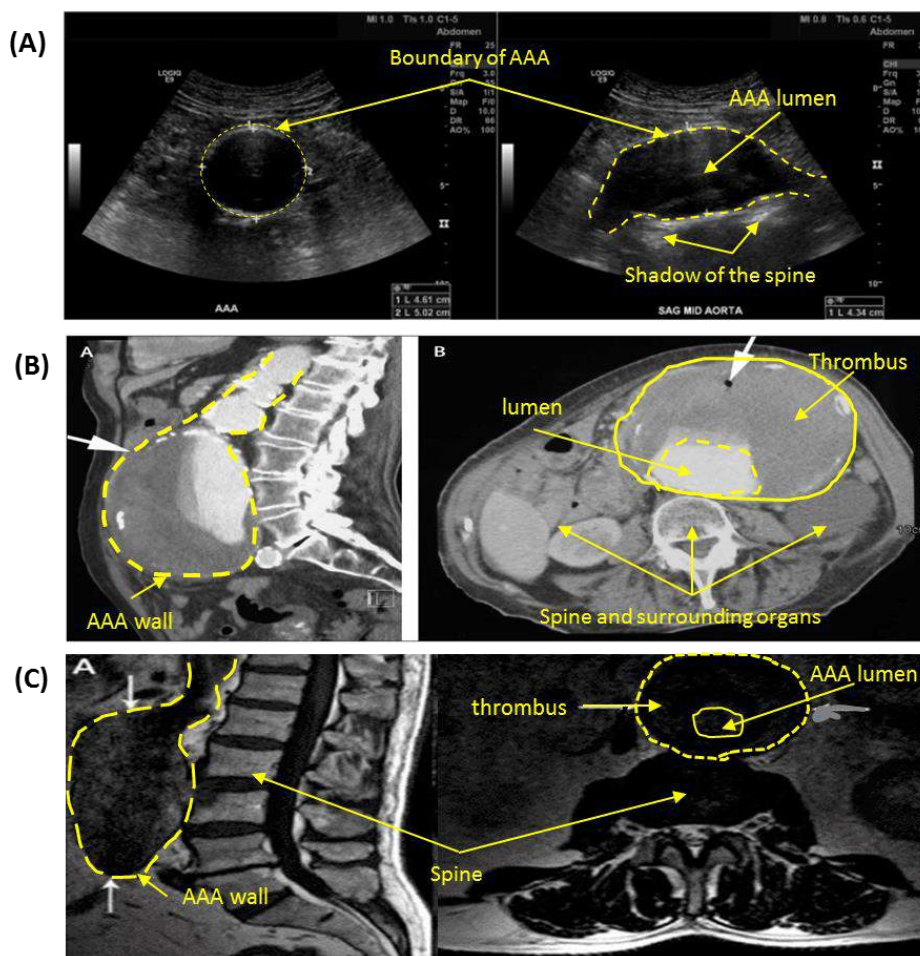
Sagittal and cross-section images of AAA represent (A) 3D ultrasound, (B) CT, and (C) MRI. [68]
